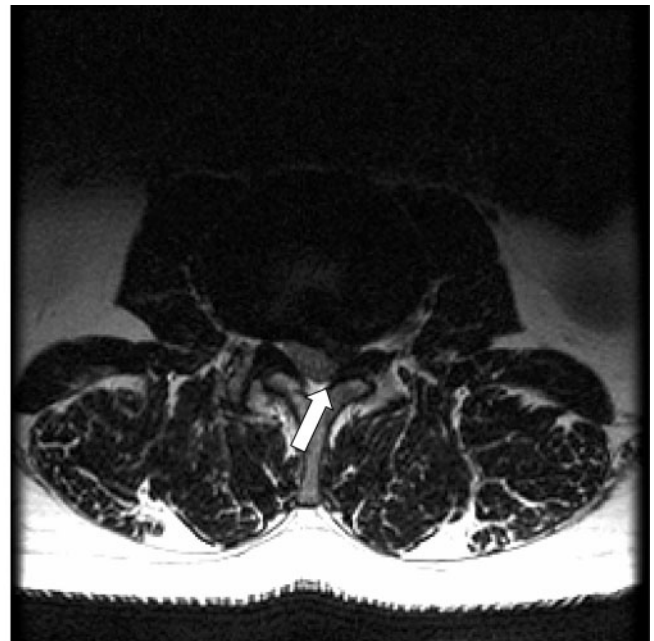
43-year-old male with left-sided lumbosacral radicular syndrome of S1. At both CT and MRI there is disagreement on root compression of L5 on the opposite side of signs and symptoms. (a) Axial CT L4–L5. Observers disagree on whether root L5 on the right (asymptomatic side), is compressed (arrow). (b) Axial  $T_2$  weighted MRI L4–L5. Observers agree on compression of L5 on the right (asymptomatic side) (arrow).
